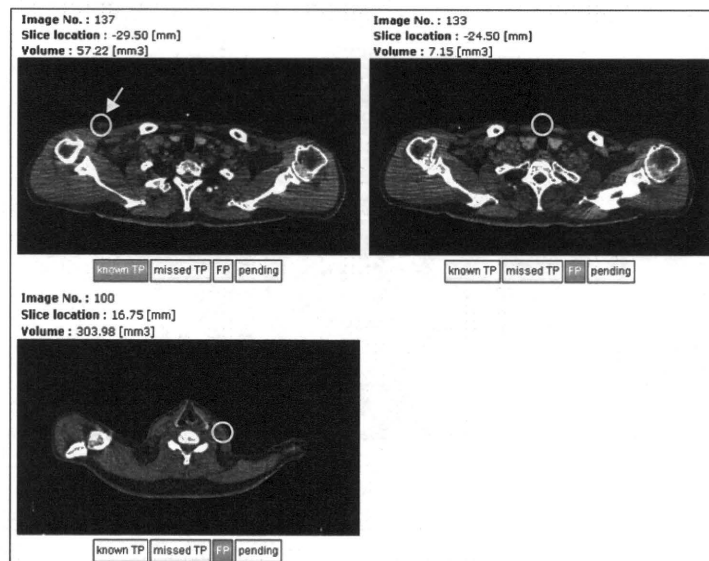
Result of skin lesion detection in whole-body FDG-PET/CT images. The center slice of the displayed candidate is displayed in a CT image. The circles indicate the location of the lesion candidate, and the circle with an arrow indicates the detected skin lesion.
